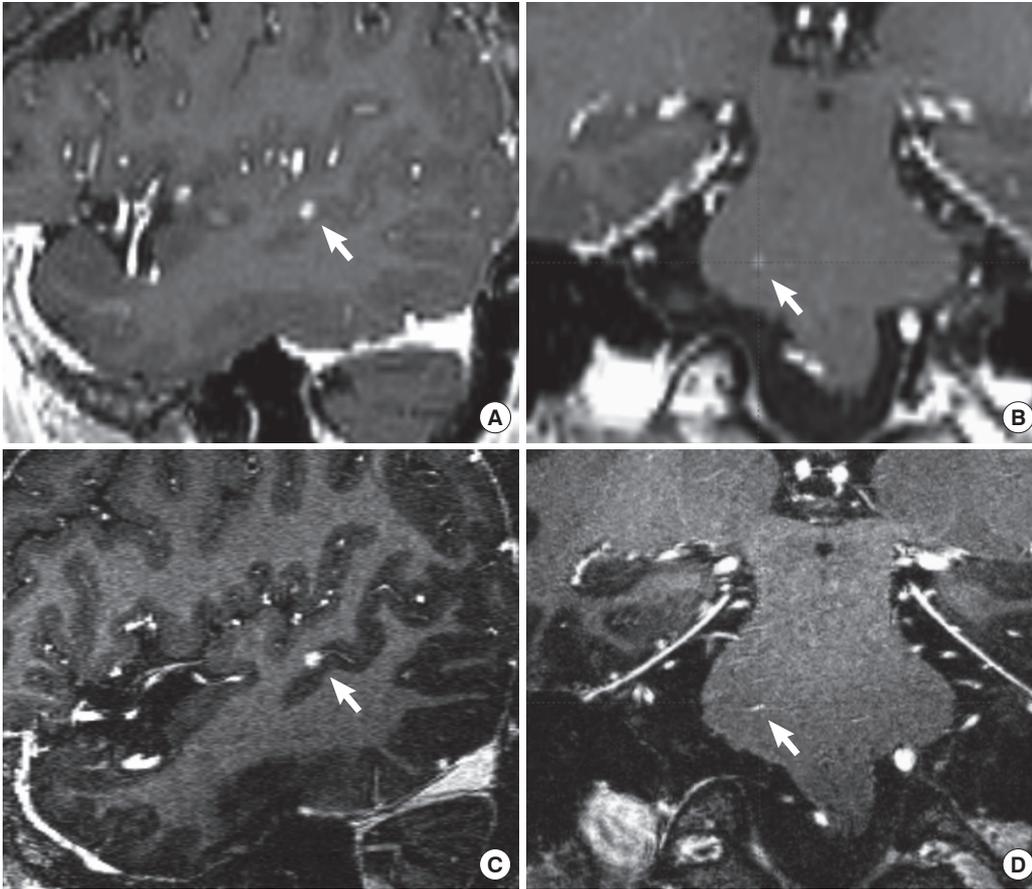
Sagittal and coronal images of metastatic lesions (arrow) in the left temporal lobe and the right side of the pons in the co-registered images of 1.5 T and 7.0 T magnetic resonance images (MRI). While only high signal intensity regions in 1.5 T MRI (A, B), blood vessels connected to the tumors are clearly identified in high resolution images of 7.0 T MRI (C, D).
